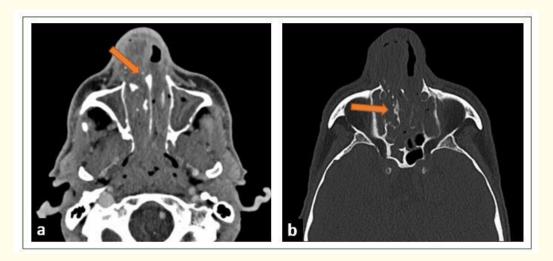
CT scan of naso-sinus, axial section, parenchymal section showing an irregular hypodense process of the right nasal cavity extended posteriorly to the nasopharynx, (a), and bone section showing bone lysis with intralesional calcifications (b).
